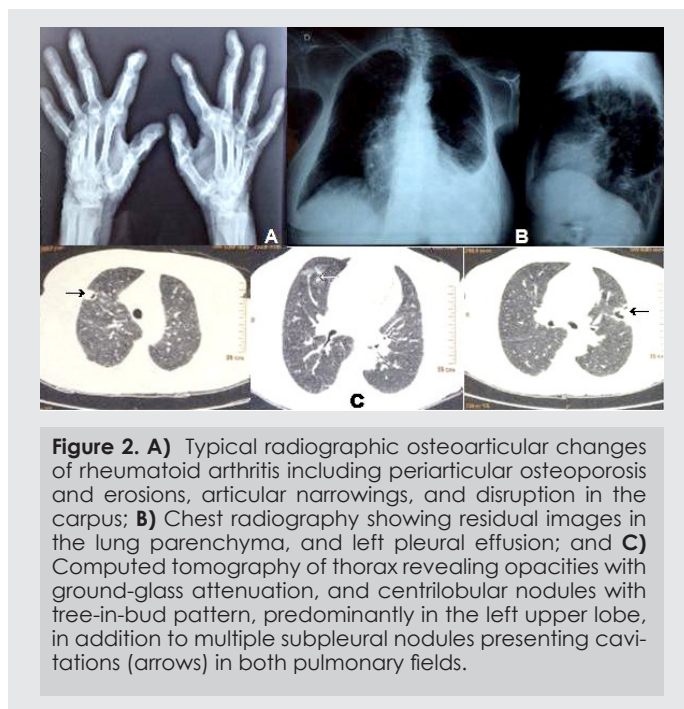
A) Typical radiographic osteoarticular changes of rheumatoid arthritis including periarticular osteoporosis and erosions, articular narrowings, and disruption in the carpus; B) Chest radiography showing residual images in the lung parenchyma, and left pleural effusion; and C) Computed tomography of thorax revealing opacities with ground-glass attenuation, and centrilobular nodules with tree-in-bud pattern, predominantly in the left upper lobe, in addition to multiple subpleural nodules presenting cavitations (arrows) in both pulmonary fields.
